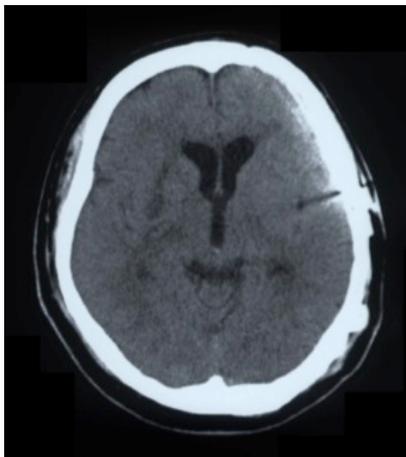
(a) CT scan image and (b) external appearance at the time of admission for cranioplasty. A depressed area was located on the temporal part of the skull.
